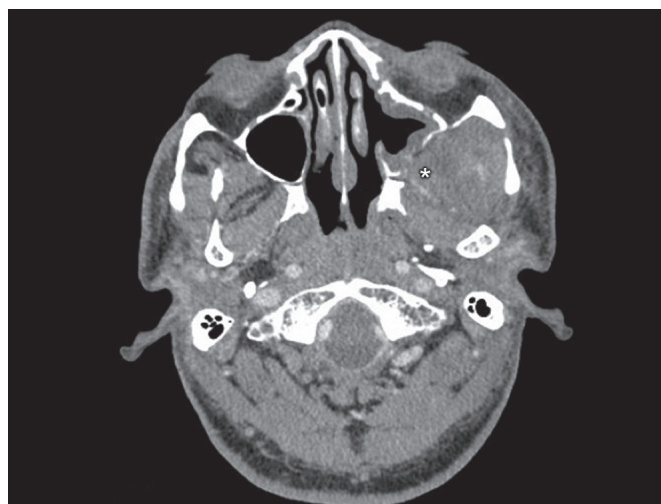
Actinomycosis of the paranasal sinuses may rarely extend to surround structure. This computed tomography demonstrates bony erosion of the posterior wall of the maxillary sinus (asterisk), with resultant involvement of the infratemporal fossa.
